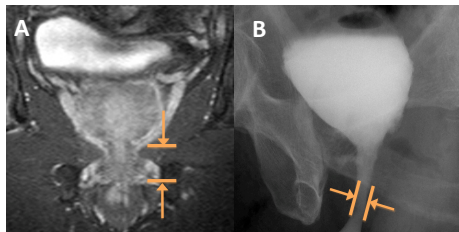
MRI and VCUg (A) Coronal image of an MRI image. Distance from prostatic apex to penile bulb represents urethral length. (B) VCUg for measuring internal diameter of external urethral sphincter.
